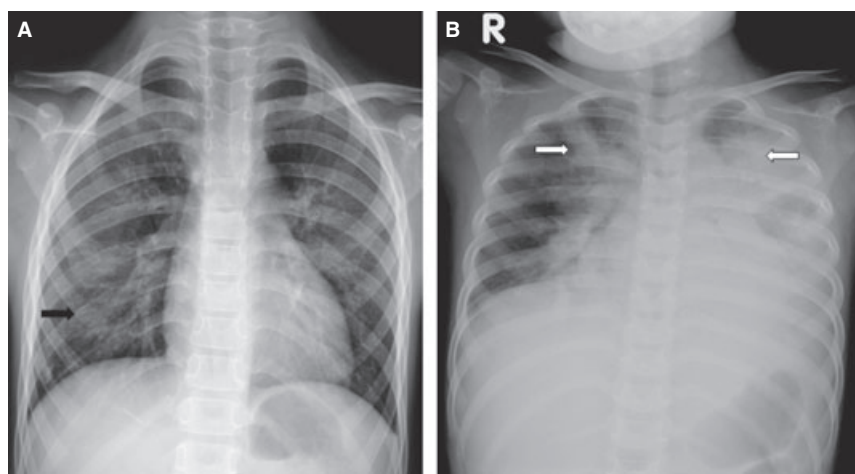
Chest radiographs showing infiltrates in the right lower lung field (black arrow) of a 8-year-old boy (A) and consolidations in both lungs (white arrows) with left pleural effusion of a 5-year-old girl (B).
